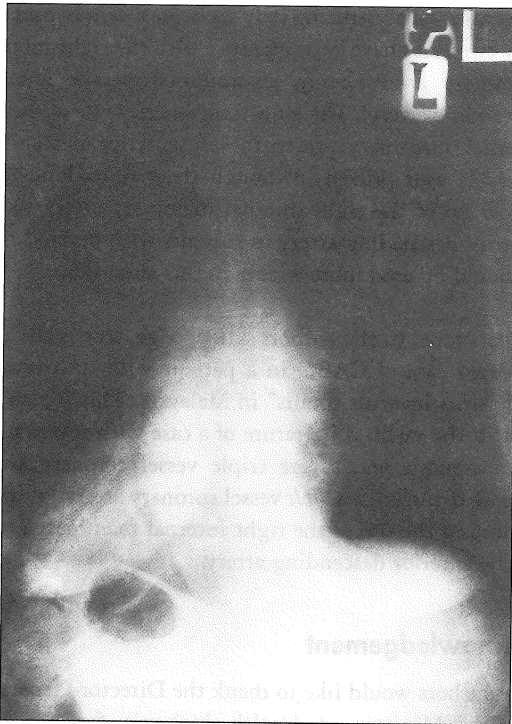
Chest radiograph showing the aortic arch, cardiac apex and gastric bubble on the right side.
